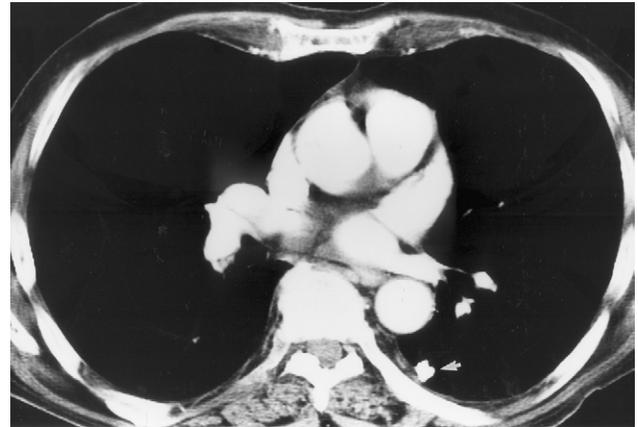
Calcified histoplasmosis Ghon lesion. Contrast-enhanced chest CT image (soft tissue window) reveals a sharply defined, irregular calcified opacity adjacent to the pleura of the left lower lobe representing a calcified granuloma (*arrow*). (The white areas within mediastinal and hilar structures represent normal enhanced vasculature.)
